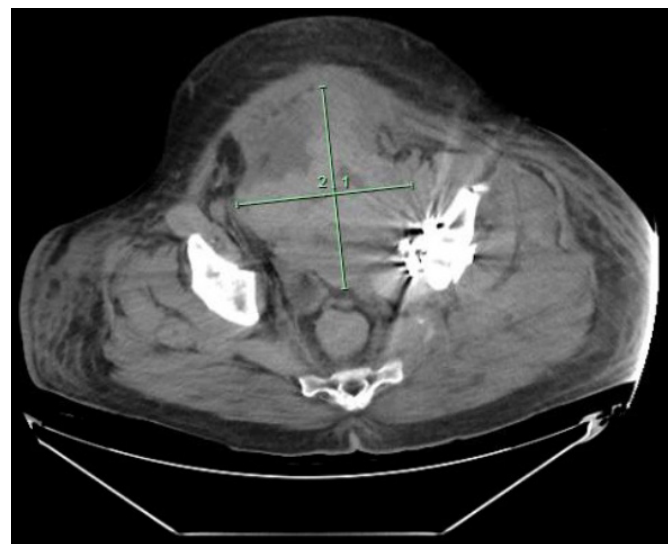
Axial CT Images Obtained on Hospital Day 12 Demonstrating Pelvic Hematoma Measuring 14.33 cm × 12.40 cm. Published with Permission
